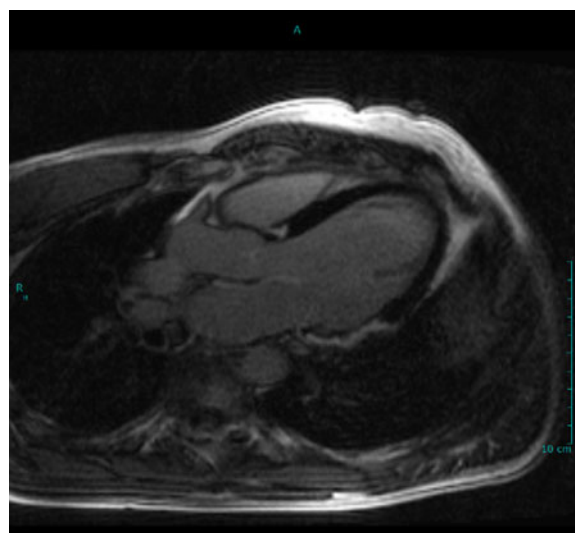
Cardiac magnetic resonance imaging with focal late gadolinium enhancement suggesting focal inflammation. There is strong accumulation of late gadolinium enhancement involving the basal and mid inferior wall and basal and mid-lateral wall as well as another focus in the basal septum. The pattern of enhancement involves the mid-myocardium and epicardium
